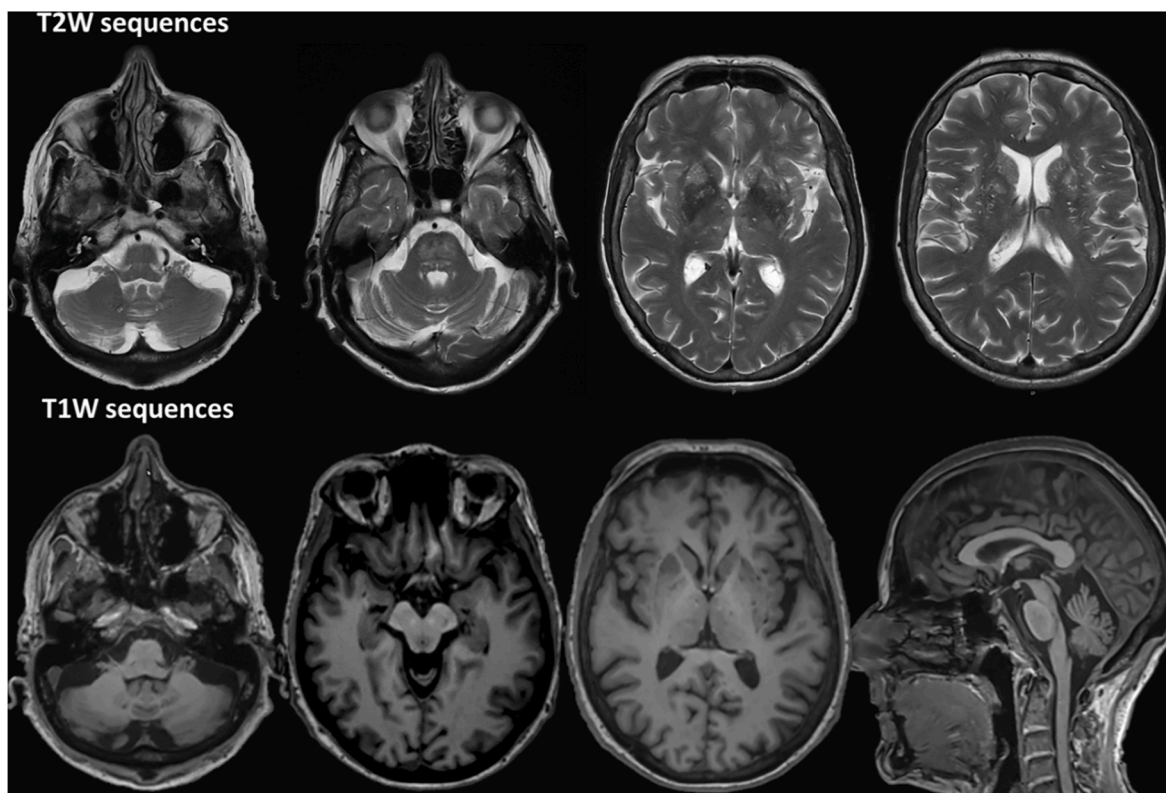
Brain MRI showing multiple small lesions with hypersignal in T2 weighted images (T2W) with small spotty lesions and cribriform changes suggestive of enlarged perivascular (Virchow-Robin) spaces in the dentate nucleus, globus pallidus and caudate nucleus. In the Pons, there were additional white matter lesions with hypersignal in T2 and variable appearance on T1 weighted images (T1W). There were no clear findings compatible with Hummingbird sign (typically seen in PSP), hot cross bun or putaminal rim signs (supportive imaging features of multiple system atrophy). Note the midline and hemispheric cerebellar atrophy in the T1-weighted-sequences.
